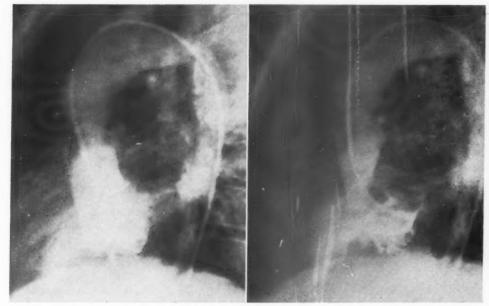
Case III. Levocardiograms in lateral projection taken in diastole and systole. The narrowed supravalvular segment of the aorta is well demonstrated. The branches of the left coronary artery are filled, the right coronary vessel became opacified later on the follow-up roentgenograms. The ascending portion of the aorta measures 3.2 cm. in diameter against the 1.6 cm. wide caliber of the descending portion. The deformed right aortic cusp is demonstrated on this roentgenogram.
